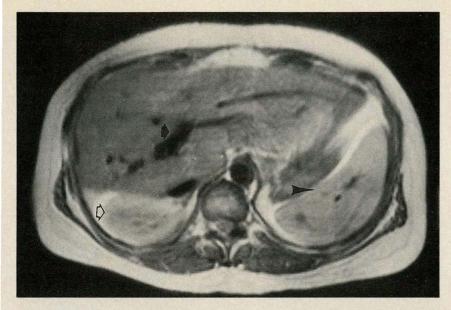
Axial T1-weighted scan of upper part of abdomen. Signal void is seen within a hepatic vessel (arrow). Open arrow indicates right kidney; arrowhead indicates spleen.
